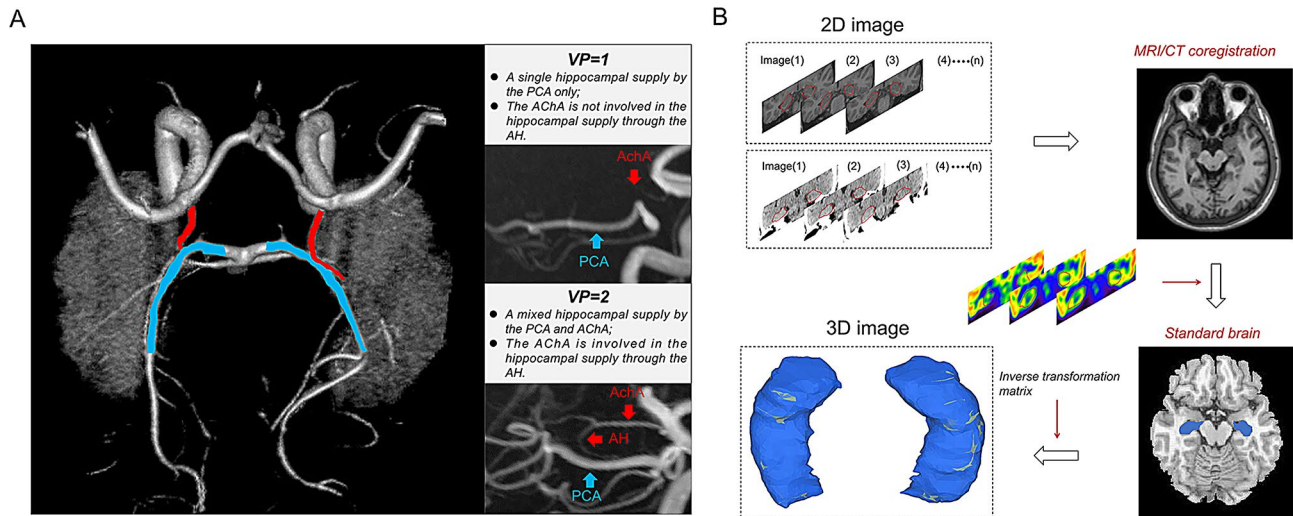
Assessment of hippocampal VP and Aβ uptake. A A 3D TOF MRA reconstruction with the hippocampal mask. On the left: main vessels involved in the hippocampal blood supply. Blue indicates the posterior cerebral artery (PCA), and red indicates the anterior choroidal artery (AChA). On the top right: A single hippocampal supply by the PCA only; the AChA is not involved in the hippocampal blood through the anterior hippocampal artery (AH). On the bottom right: A mixed hippocampal supply by the PCA and AChA; the AChA is involved in hippocampal supply through the AH. B 3D imaging of hippocampal PiB uptake. Registering the CT image to the MRI. Integrating the PET image into the resulting MRI/CT fused imaging space to generate PET/CT and MRI registration. Normalizing the registered images to the Montreal Neurological Institute (MNI) space and applying smoothing. Extracting and calculating the PiB uptake of the entire hippocampal region, followed by reconstruction and spatial visual assessment of Aβ quantification on a 3D view
